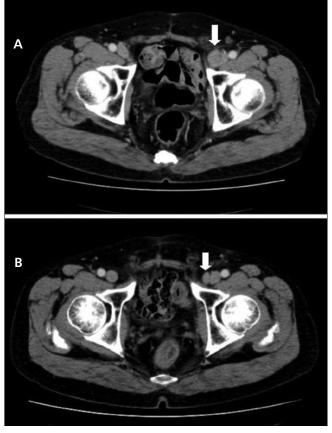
A. (top), A CT scan shows the swollen left inguinal lymph nodes with maximum size of 2cm in diameter. B. (bottom), The maximum size of the lymph nodes decreased to 8 mm in diameter due to secondary hormonal therapy.
